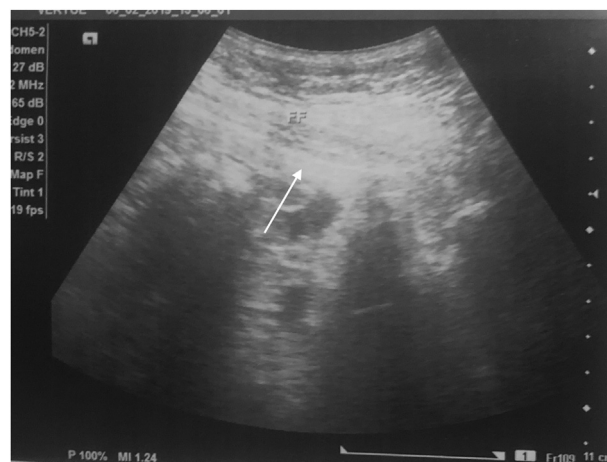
Abdominal ultrasound showing free fluid in the abdomen and pelvis, white arrow.
